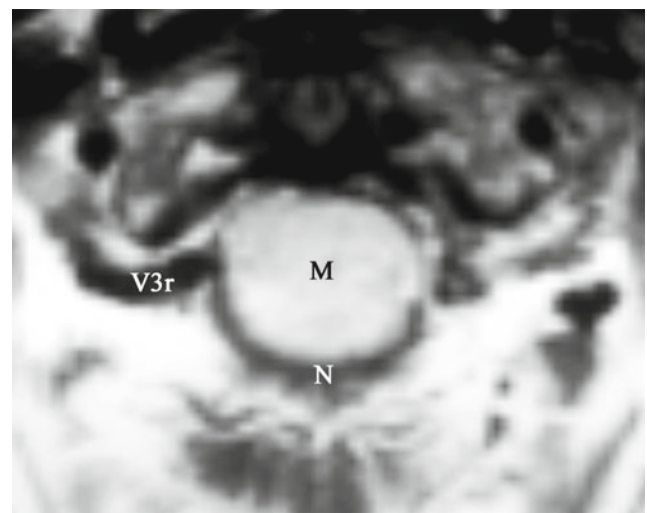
Anterior meningeoma developed below the VA. A–D. Preoperative workup. A. Axial T1-weighted MRI with gadolinium. Relations between the tumor, neuraxis, and both VAs are well observed. B. Sagittal view. C. Coronal view. Clearly the right VA V4 segment runs above the meningeoma. In this condition, the lower cranial nerves will be found at the superior pole of the tumor at surgery. Notice the dura mater (*arrow*) of the foramen magnum lateral wall that forms at the level of the occipital condyle the dural ring at the junction between the V3 and V4 segments of the VA. At this level, a venous plexus is observed surrounding the artery. D. Same coronal view on T2-weighted MRI. E–M. Operative views. E. Posterolateral approach with lateral suboccipital craniotomy and C1 laminectomy extended on the pathological side to the lateral mass after control of the horizontal portion of the VA V3 segment (located between the tip of the bipolar forceps and the sucker) and contralaterally apart from the midline. F. The dura mater has been incised exposing the neuraxis, the right cerebellar hemisphere and the tumor. Notice the C2 posterior rootlets, the accessory nerve, and a C1 posterior rootlet branch joining it (*black arrow*). Cutting the dentate ligament at this step is important to release the spinal cord and improve the access to the tumor. G. Because the meningeoma grows below the VA and lower cranial nerves are displaced upward, the resection has to start at the inferior pole. It allows also to divide the blood coming from a dural branch of the third interspace. The arachnoid has been incised and fixed to the dura mater with a vascular clip (*arrow*). H. The lesion is then incised and debulked. Notice the posterior spinal artery crossing the posterior aspect of the meningeoma. I. The left VA V4 segment is identified by mobilizing the tumor medially. This maneuver can only be done safely after tumor debulking in order to avoid an increased pressure on the neuraxis. J. The tumor is progressively separated from the neuraxis. Retraction is never apply on the neuraxis itself. A blade is now used to prevent the fall of the cerebellum hemisphere and improve the access to the superior aspect of the lesion. K. Tumor debulking progresses. L. View after complete resection of the lesion. Both VA V4 segments are visible. The lower cranial nerves are well visible. Notice the base of insertion of the tumor at the anterior aspect of the foramen magnum dura mater. M. View before dural closure when the dura mater is turned down. N–O. Postoperative MRI after complete tumor resection. Ar: arachnoid. B: meningeoma base of insertion. Bl: blade. C1: lateral mass of atlas. C2PR: C2 posterior rootlets. C2sp: spinous process of the axis. Cer: cerebellum. DL: dentate ligament. DM: dura mater. JT: jugular tubercle. N: neuraxis. T: tumor. PSA: posterior spinal artery. X: vagal nerve. XI: accessory nerve. XII: hypoglossal nerve. V3h: horizontal portion of the vertebral artery V3 segment. V3o: oblique portion of the vertebral artery V3 segment. V4l: left vertebral artery V4 segment. V4r: right vertebral artery V4 segment. VP: venous plexus.
